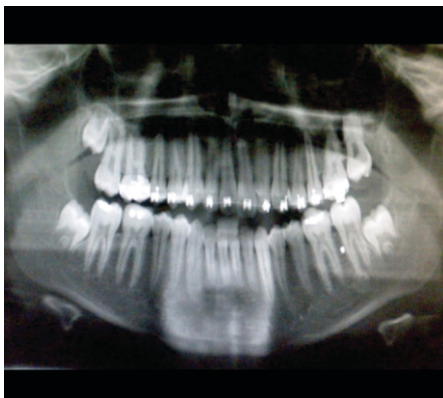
Follow Up Orthopantomogram Showing Left Maxillary First Molar in Occlusion
